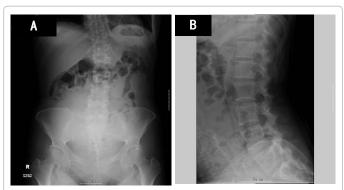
Standing lumbar spine anteroposterior (A) and lateral (B) X-ray images in the nonpregnant state showing kyphoscoliosis.
